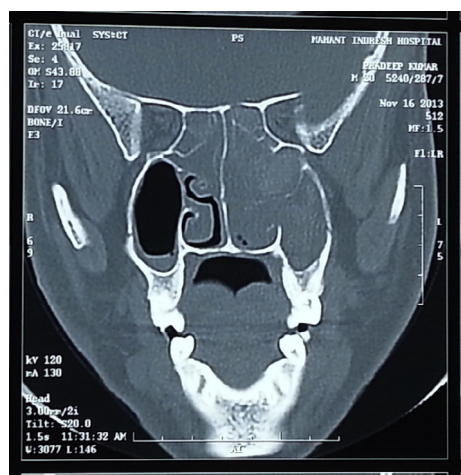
CT scan of paranasal sinuses showing bilateral diffuse sinonasal polyposis.
